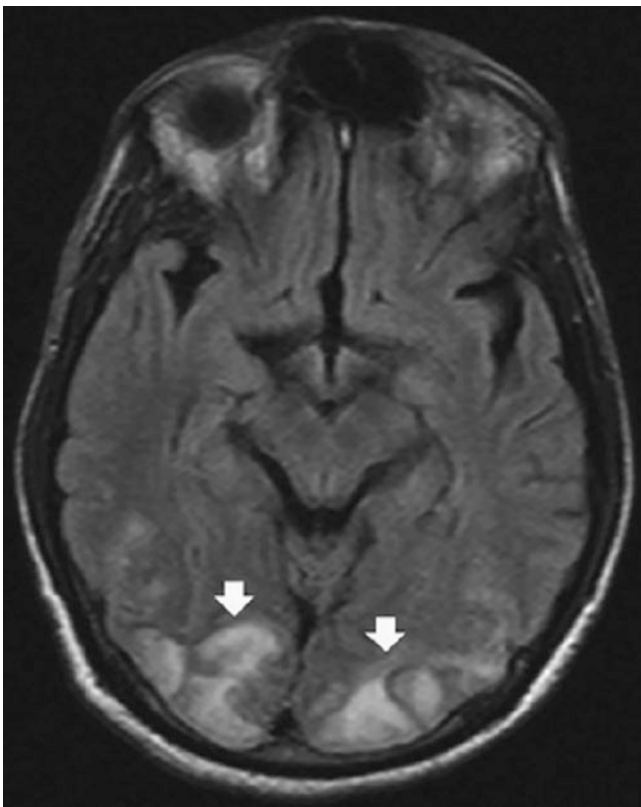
MRI of the brain revealing posterior reversible encephalopathy syndrome (PRES). Arrows point at vasogenic edema that is considered reversible
